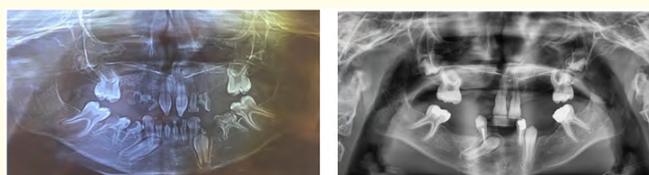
Panoramic radiograph revealed absence of eighteen teeth except third molars.
